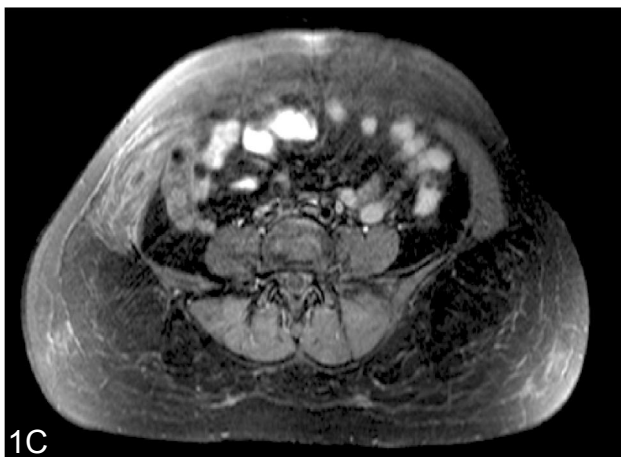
Post contrast T1-weighted fat-saturated MRI shows hypointense lesion with inflammation in internal oblique muscle.
